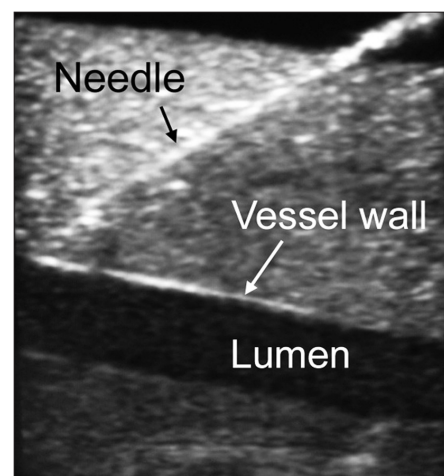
Real time imaging of needle and vein in longitudinal ultrasonic plane in the training model
